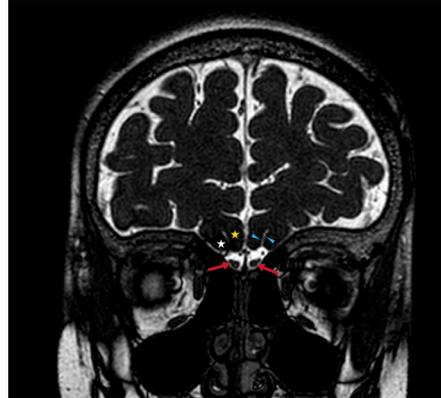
Coronal three-dimensional balanced fast-field echo magnetic resonance images of a 6-year-old girl showing the right and left olfactory bulb as a hypointense ovoid structure (arrows). The olfactory sulcus is displayed as a hyperintense line between the medial orbital gyrus (white star) and gyrus rectus (yellow star). Note the hyperintense cerebrospinal fluid surrounding the olfactory bulbs.
